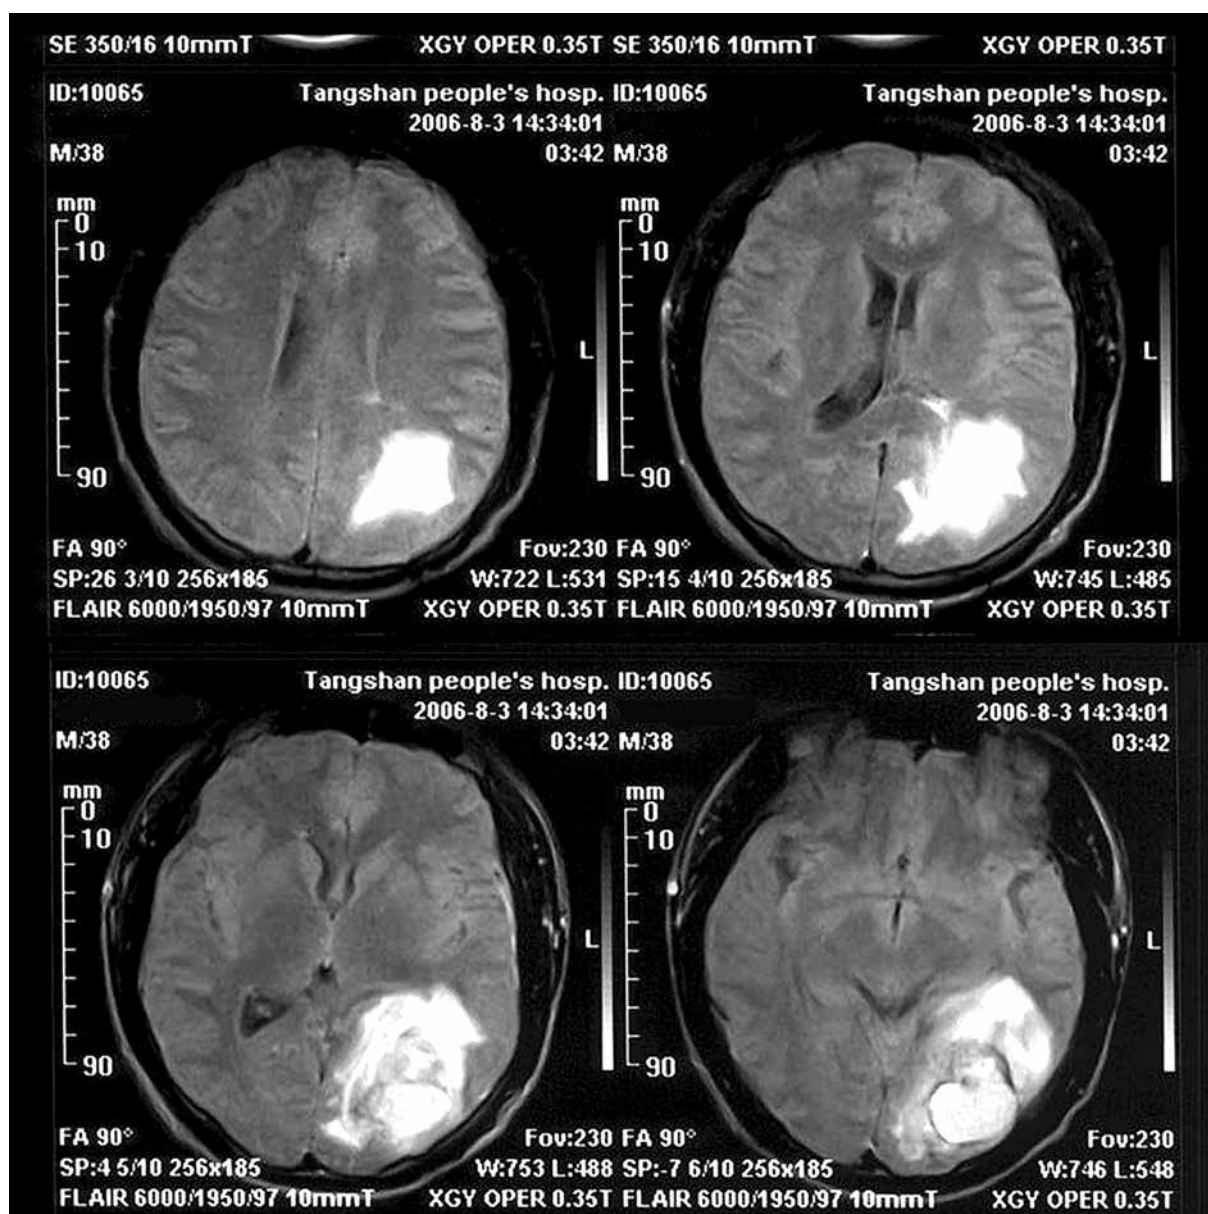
Magnetic resonance (MR) images of one case of atypical teratoid/rhabdoid tumor. The fluid-attenuated inversion recovery (FLAIR) axial MR images show a temples-parietal-occipital borderline mass with a cystic component of hyperintensities and a solid contrast-enhanced component (A1-A4) and with peripheral edema.
